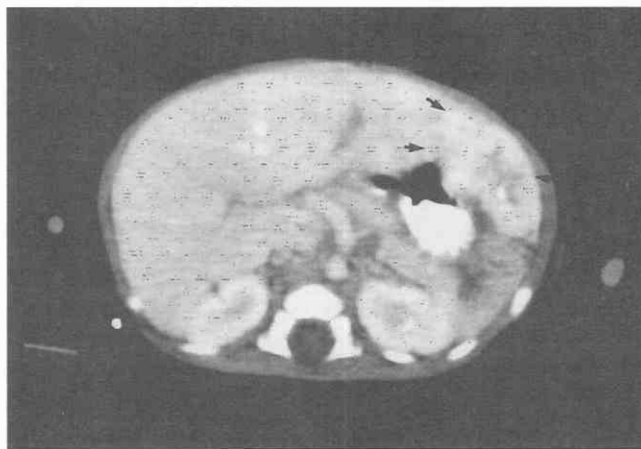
Hemangioendothelioma. CT of the upper abdomen demonstrates a lesion in the left lobe of the liver (arrows) with peripheral enhancement and central low attenuation due to hemorrhage or necrosis within the hemangioendothelioma.
